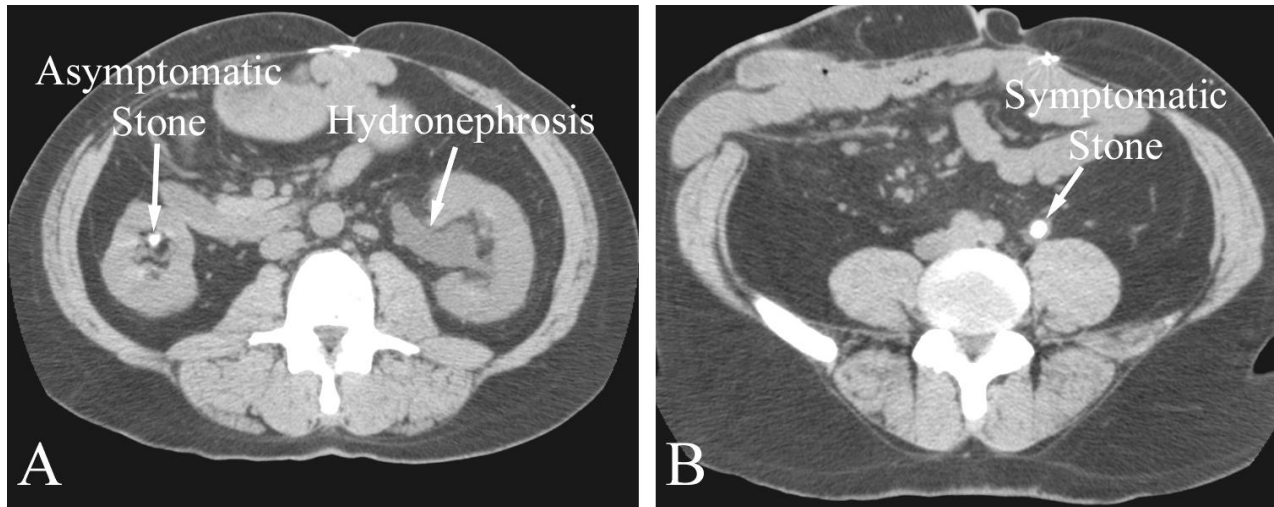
Renal stone disease and hydronephrosis in a 62 year old man with known stone disease and new onset left flank pain. A. CT-KUB at the level of the left collecting system shows hydronephrosis. Note contralateral, nonobstructing calculus. B. CT-KUB at the level of the ureteropelvic junction shows an obstructing renal stone.
